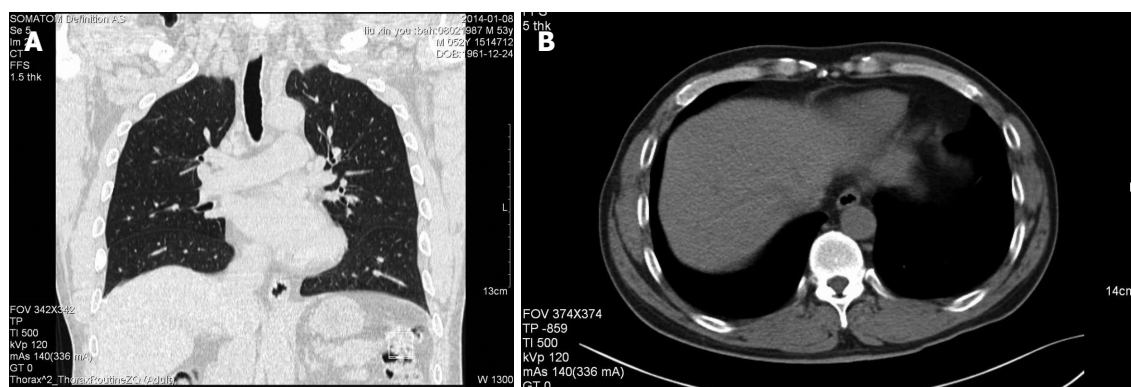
Computed tomography. A: Frontal abdominal contrast-enhanced computed tomography (CT); B: Transversal abdominal CT demonstrating a homogeneous, low-density and well-circumscribed, subserosal cystic mass on the lesser curvature of the gastric cardia.
